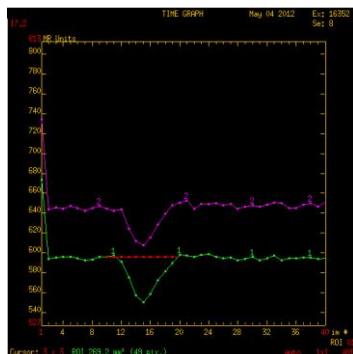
Paramagnetic curve tracer dynamics compared right / left sequence obtained in perfusion MRI.
